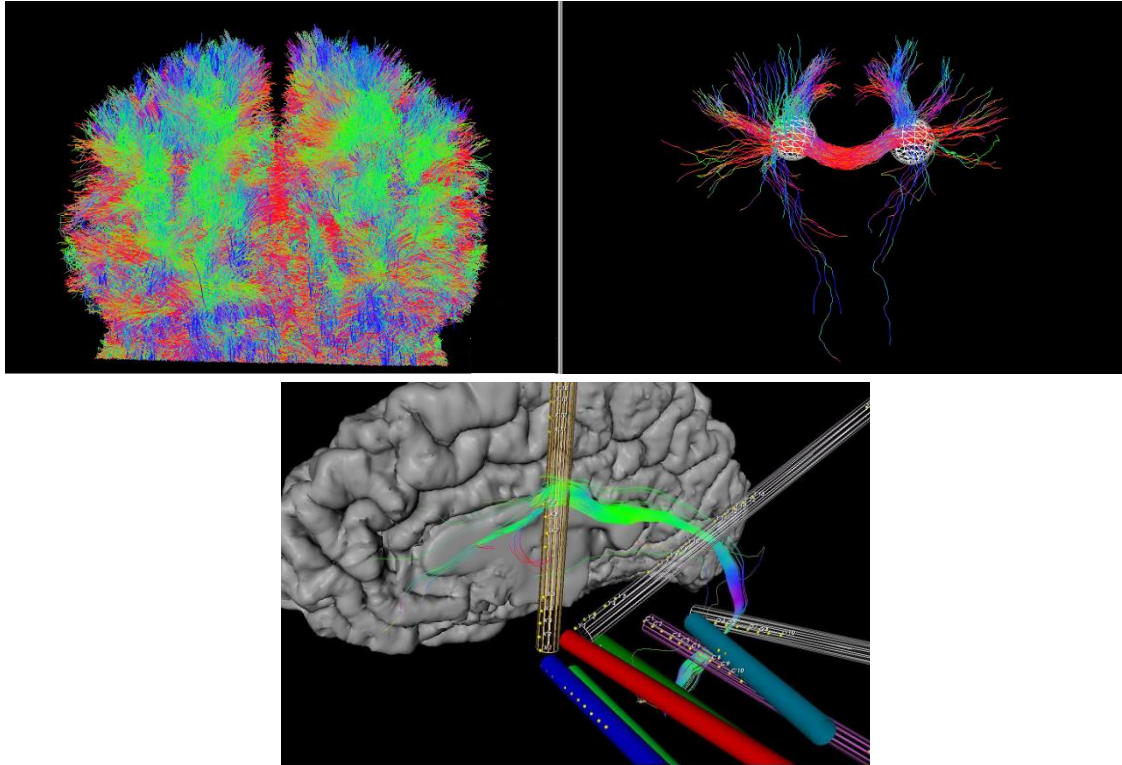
Top: a whole-brain tractography before and after being filtered with two spherical ROI with the AND operation. Bottom: A filtered DWI tractography, displaying only the tracts which traverse the four selected electrodes security zones (in wireframe). The final contact position segmented from CTpost is displayed (yellow spheres).
